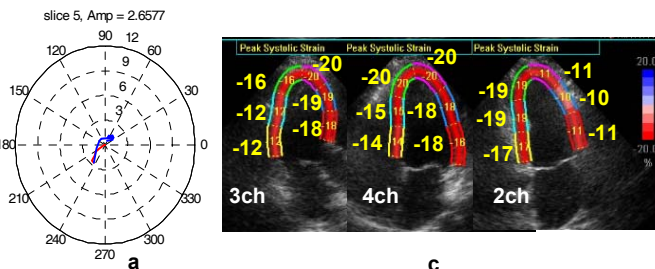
(a) A normal volunteer CPT map (2.7mm), (c) Echocardiography strain map in 3, 4, 2-chamber views.
